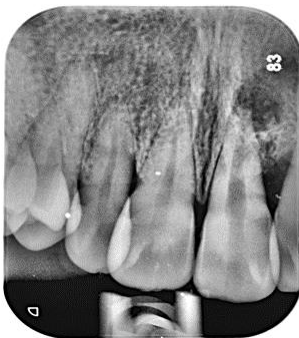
preoperative intraoral radiograph shows a periapical radiolucency related to 21
